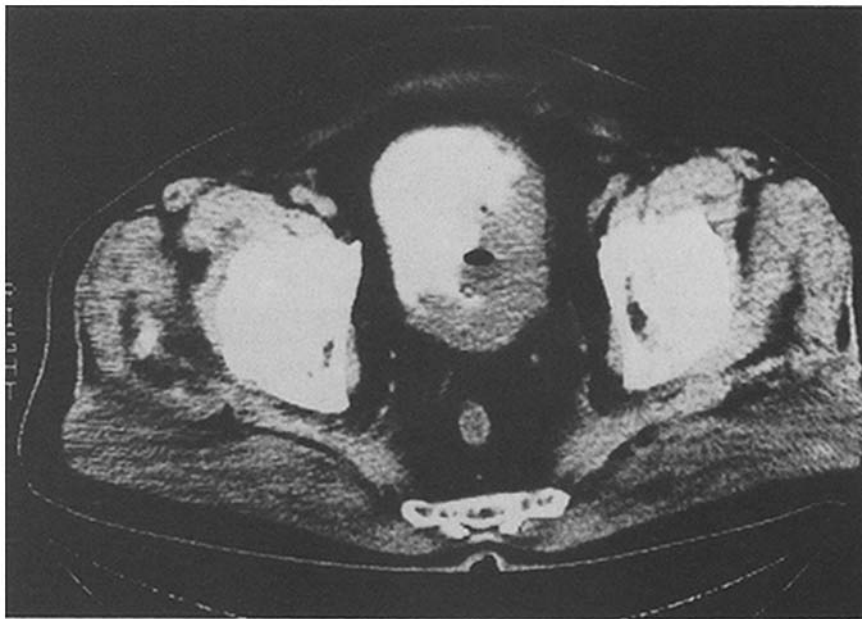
Pretreatment CT scan of case 13
